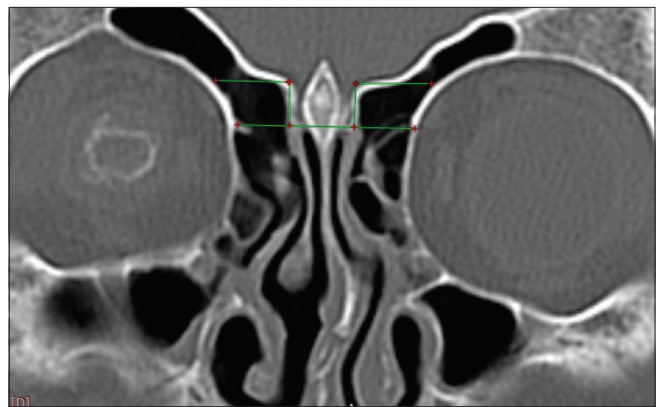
Coronal CT demonstrating type II Keros classification. Olfactory fossae are deeper and the lateral lamellae are longer than in type I
